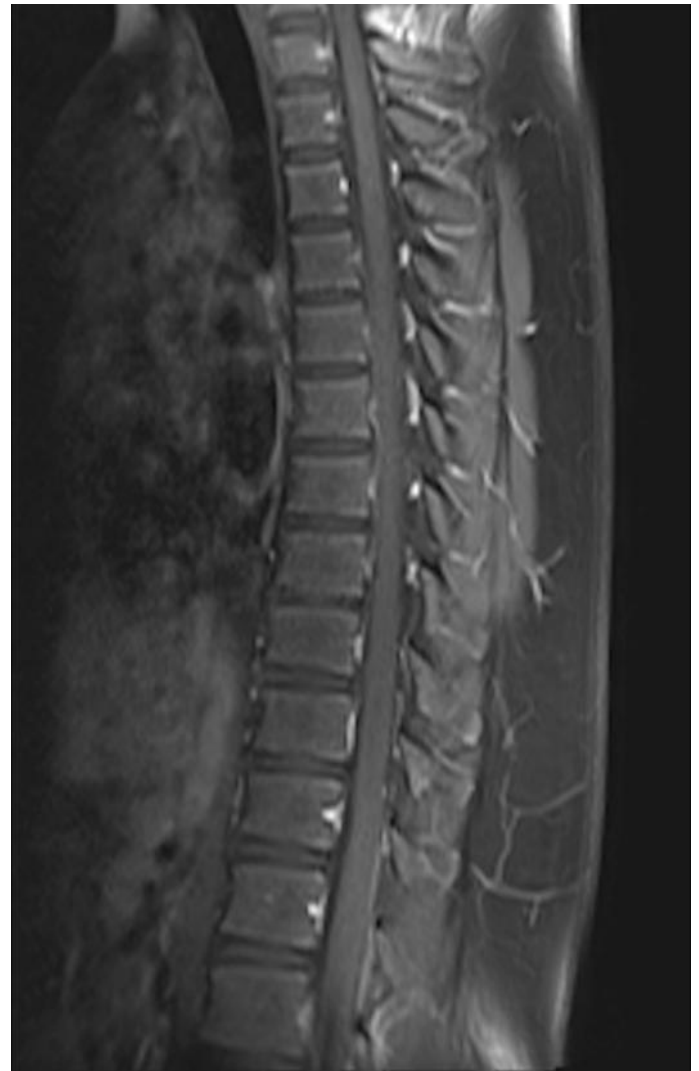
Sagittal MRI of the thoracolumbar spine at day 2 of hospitalization. Sagittal T2W image (A) reveals an expanded spinal cord from T8 to conus medullaris with abnormal increase signal representing cord edema. Sagittal T1 image following intravenous administration of gadolinium (B) demonstrate no abnormal contrast enhancement.
